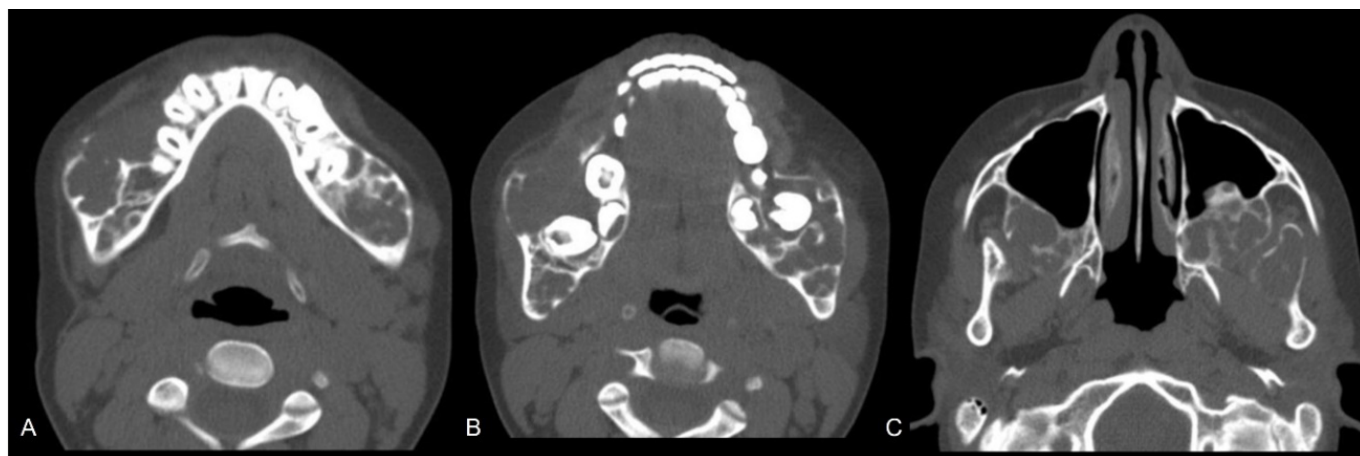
Axial computed tomography scan revealing bilateral multilocular osteolytic lesions in the mandible and maxilla, associated with bone expansion and cortical thinning.
